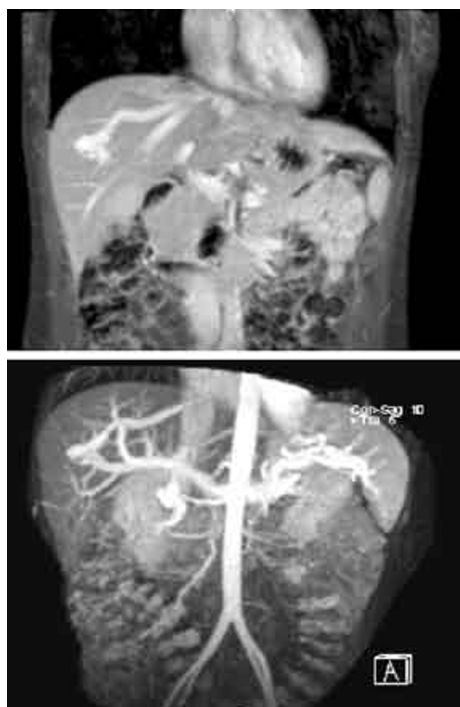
CT venogram, coronal view. Presence of a vascular anomaly within the anterior aspect of the right liver, this is characterized by a portosystemic shunt from the anterior division of the right portal vein into the middle hepatic vein via the segment 8. The size of the nidus of the anomaly measures up to 24 mm.
